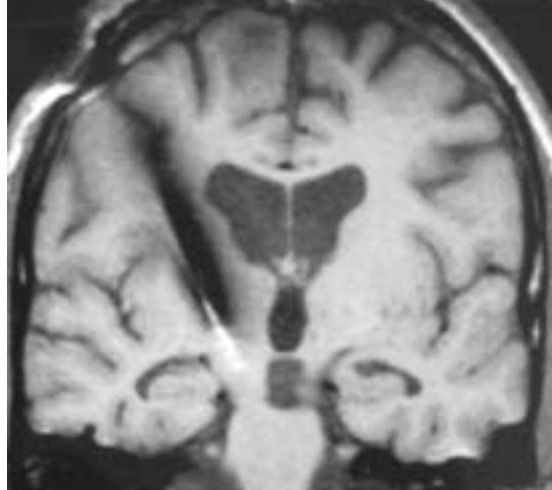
A coronal MRI showing the deep brain electrode in situ.
